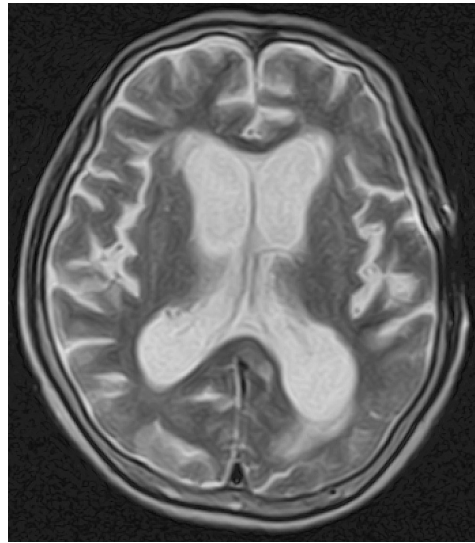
A T2-weighted axial non-contrast brain magnetic resonance image shows increased ventricular volume not proportionate to enlargement of cortical sulci.
